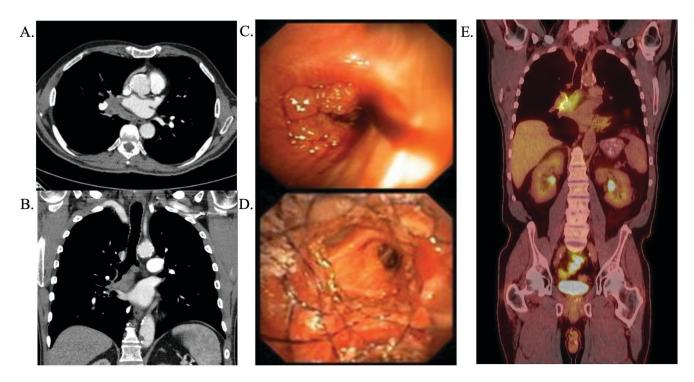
Computed tomography (CT) chest revealing tumor invasion with intraluminal thrombus of the right superior pulmonic vein (A and B). Bronchoscopy revealing luminal compromise (C) prompting tracheal stent placement (D). Positron emission tomography (PET) imaging ultimately showed increased tracer uptake concerning for malignancy (E).
